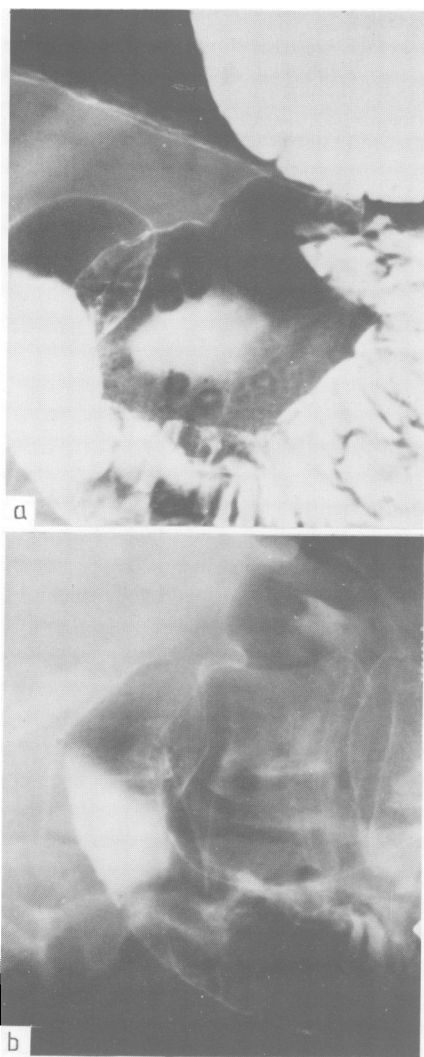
Figure Case 2. Representative radiographs from double contrast barium meal examinations. (a) Classic lesions of chronic erosive gastritis in the gastric antrum. (b) Complete resolution after treatment with oral prednisolone.
